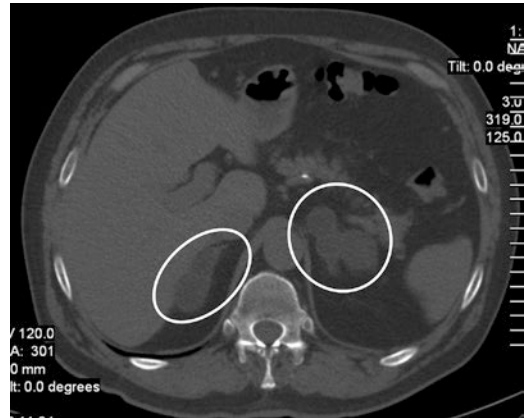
CT scan of a bilateral macronodular adrenal hyperplasia (BMAH). Note the large nodules especially in the left adrenal
